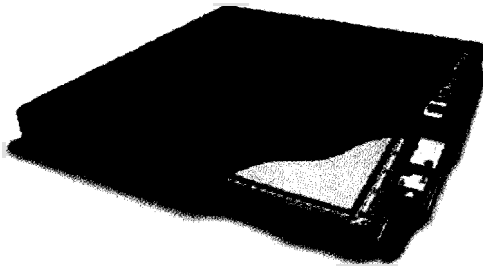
The DirectRay® detector from Direct Radiography Corp. (now a subsidiary of Hologic Inc.). Its a 35×43 cm^2 unit employing a-Se and TFT readout technology. Both the (encapsulated) detector panel and the controller logic are visible [50].
